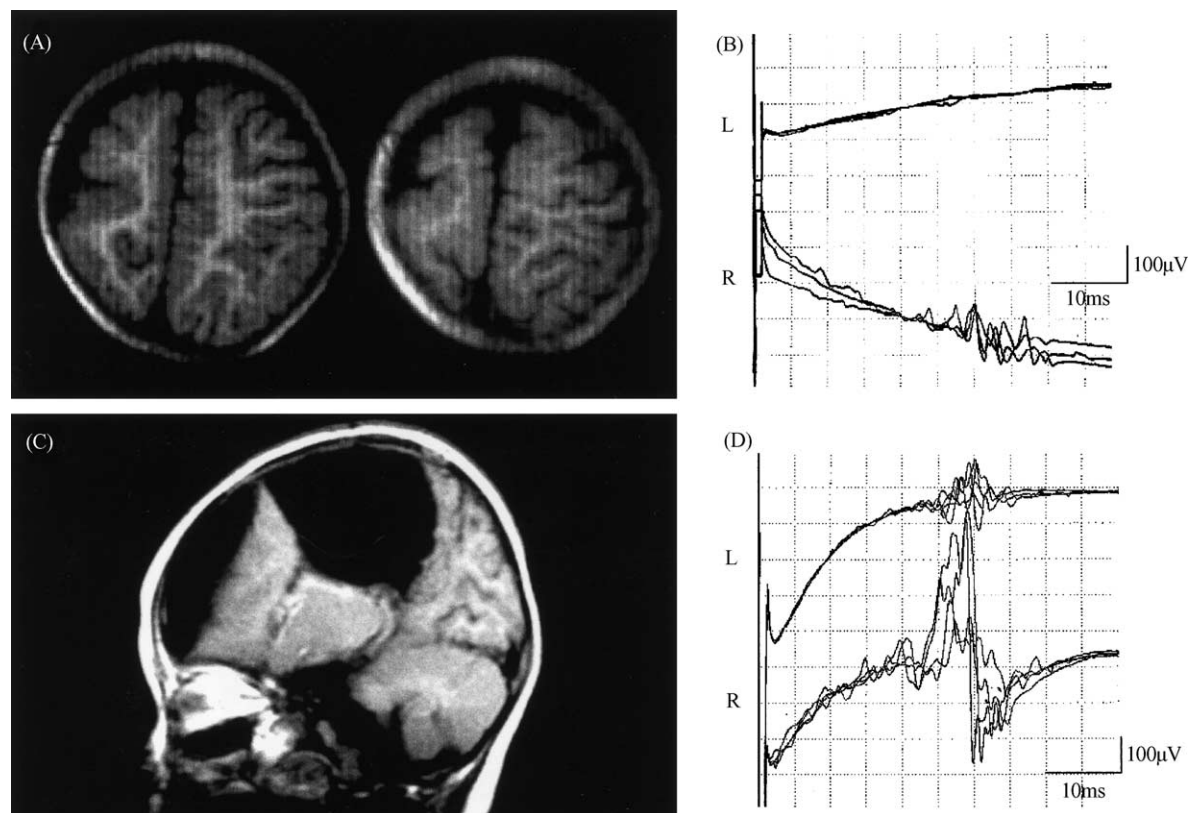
(A–D) T₁-weighted magnetic resonance images showing lissencephaly in the right hemisphere (A; case 1). MEPs from bilateral recording of APB muscles following TMS using a circular coil before surgery (B). Sagittal magnetic resonance image showing functional hemispherectomy (C). MEPs from bilateral recordings of APB muscles after surgery (D).
